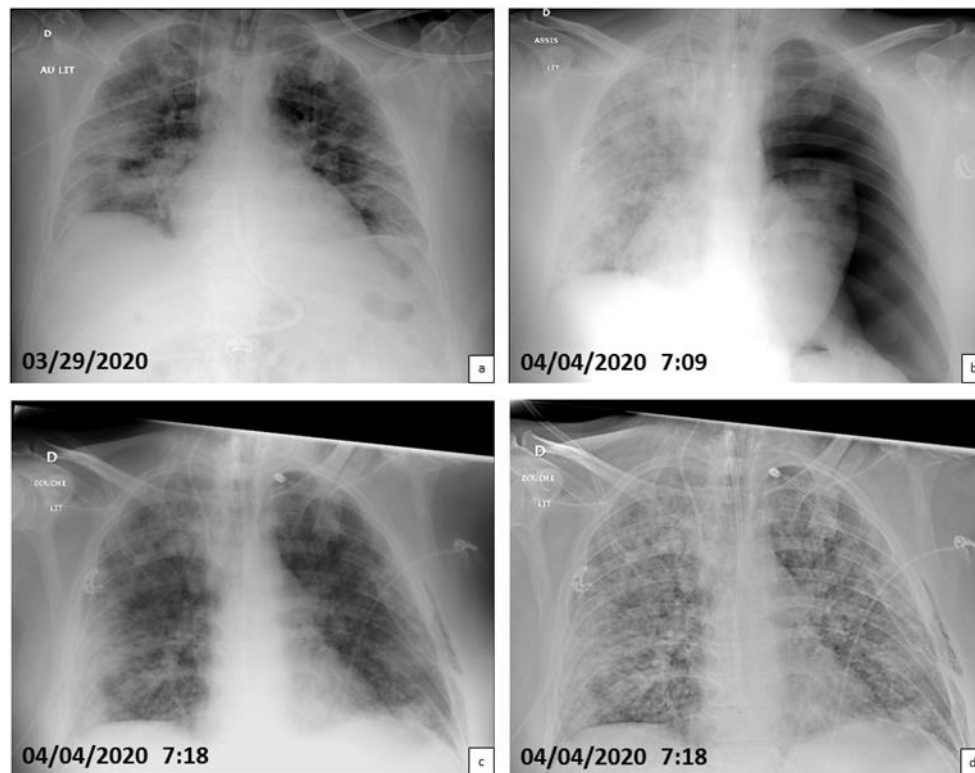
Complete pneumothorax in a 51-year-old COVID-19 patient. a: initial bed chest X-ray (day 9 since symptoms) showing lesions of COVID-19 pneumonia (bilateral ground glass opacities with consolidations). b: Chest X-ray showing a left complete pneumothorax with a collapsed lung. c: chest X-ray after successful drain placement, with “soft-tissue filter” used for parenchymal analysis, showing total expanded left lung d: same picture as in Figure 1c with “hard filter” the better contrast is useful for tubes screening (large arrows).
